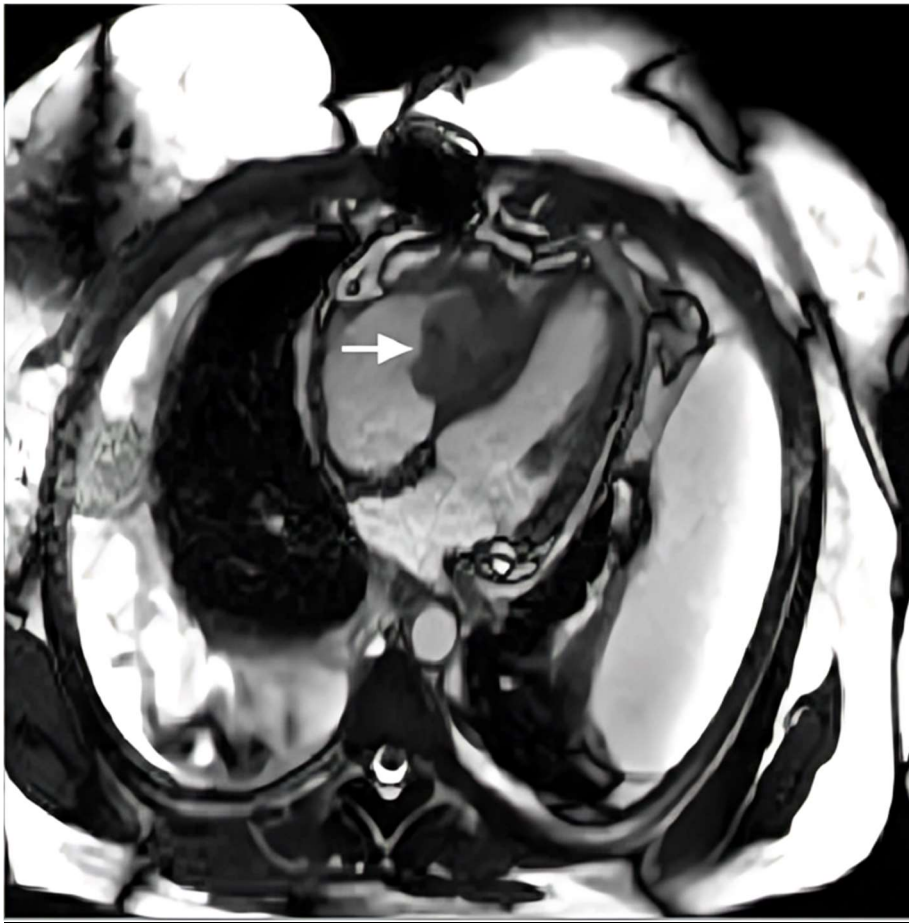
Cardiac magnetic resonance image shows a right ventricular angiosarcoma (arrow)
